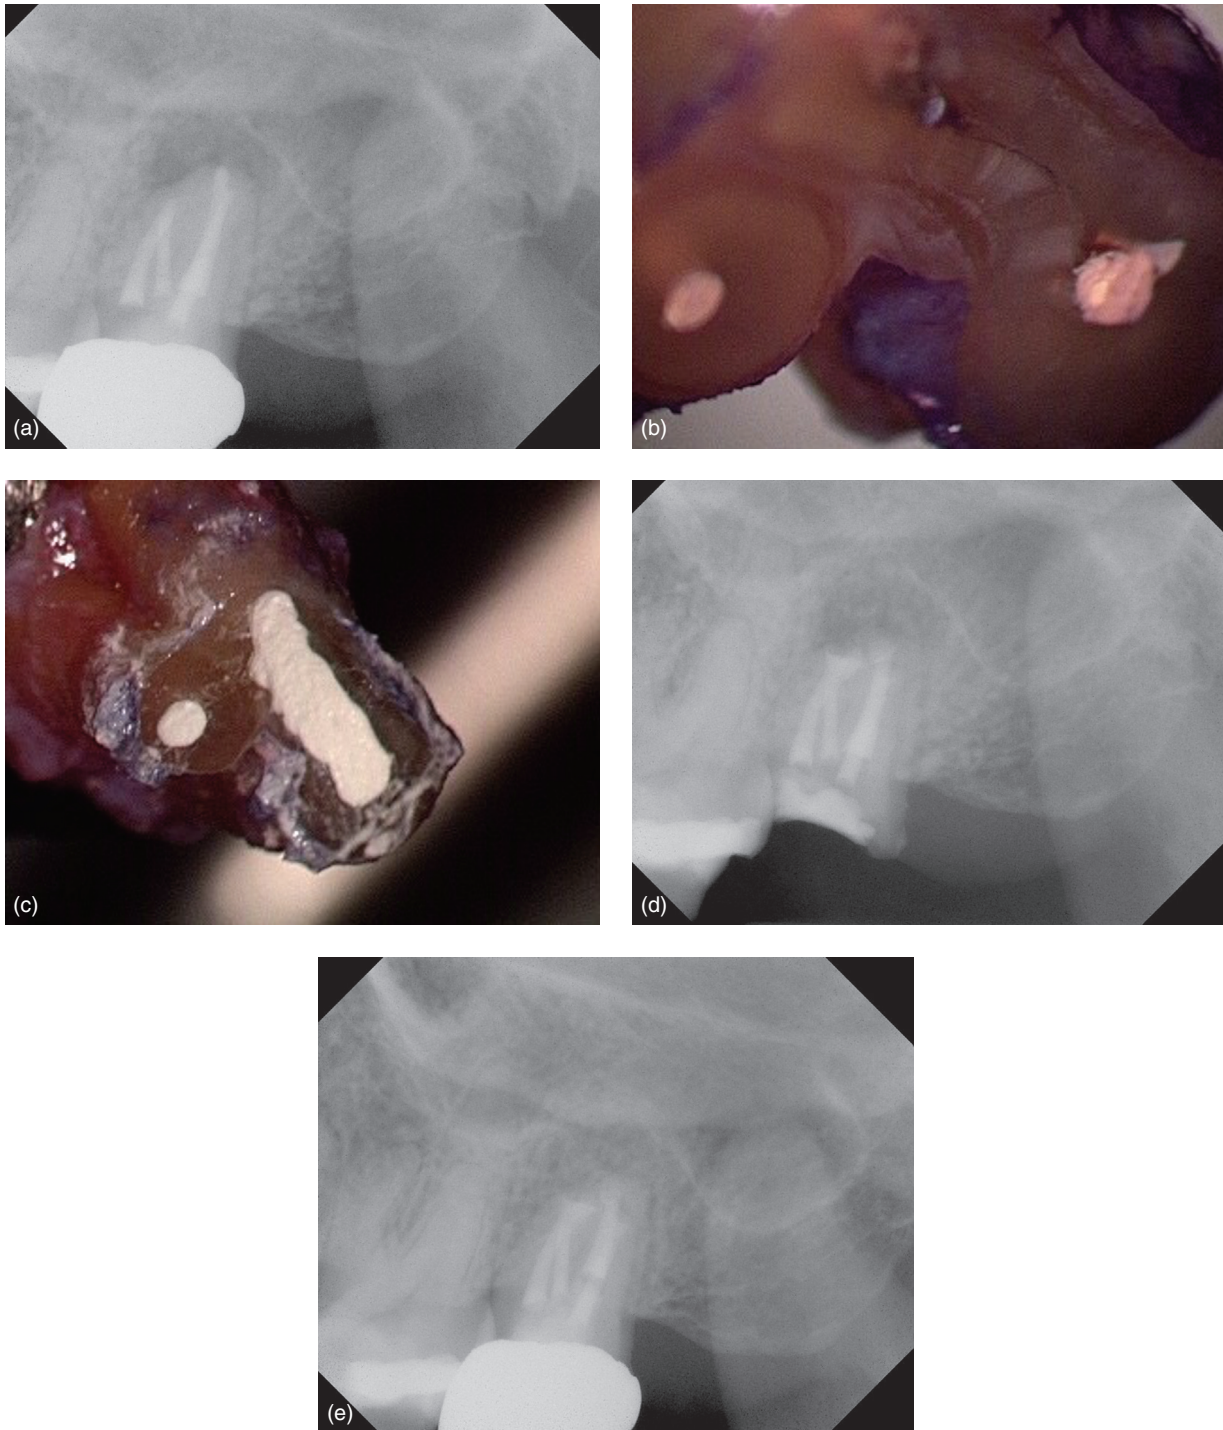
Maxillary left second molar with failing endodontic treatment. (a) Preop radiograph; (b) a long fin (isthmus) connecting MB and palatal roots; (c) root end preparations, incorporating the long isthmus, filled with fast-set Bioceramic putty; (d) Postop radiograph (note that the crown had fallen off during the procedure, but was recemented following initial healing); (e) 6 month follow-up radiograph showing osseous healing.
